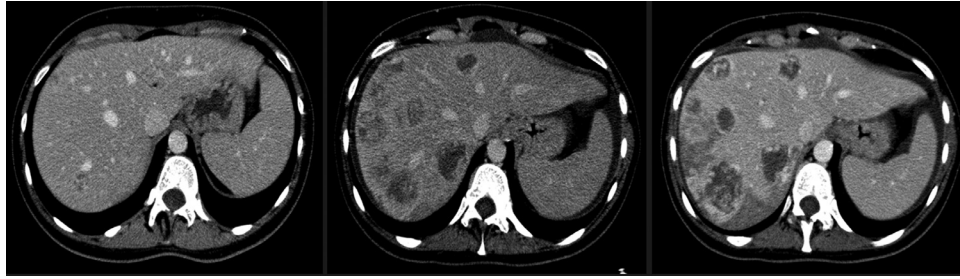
Choriocarcinoma syndrome development. Axial contrast-enhanced CT image, venous-phase, from subsequent CT controls in about 2 weeks, shows (from left to right) increasing and necrotic-hemorrhagic aspects changes of hepatic metastasis with development of bleeding and large subcapsular hematoma in the right liver induced by tumor hypervascular nature, configuring a framework of choriocarcinoma syndrome.
